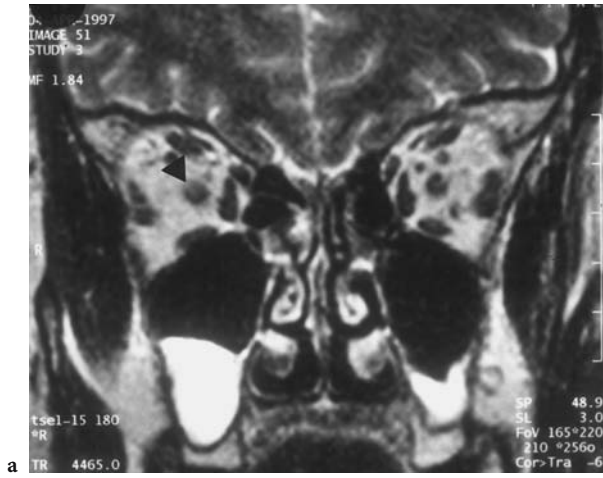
A 50-year-old man with first occurrence of right-sided loss of vision. Diagnosis: retrobulbar neuritis as the first manifestation of multiple sclerosis. MRI: a Coronal T2-weighted image with sharp signal enhancement of the right optic nerve (*triangle*). b Corresponding T1-weighted, contrast-enhanced (FS) image showing distinct enhancement of the right optic nerve. c Axial proton density intracranial view with demyelination in the region of right optic radiation. d Corresponding T2-weighted FLAIR image with typical paraventricular demyelination. (a, b with permission of MÜLLER-FORELL 1998)
